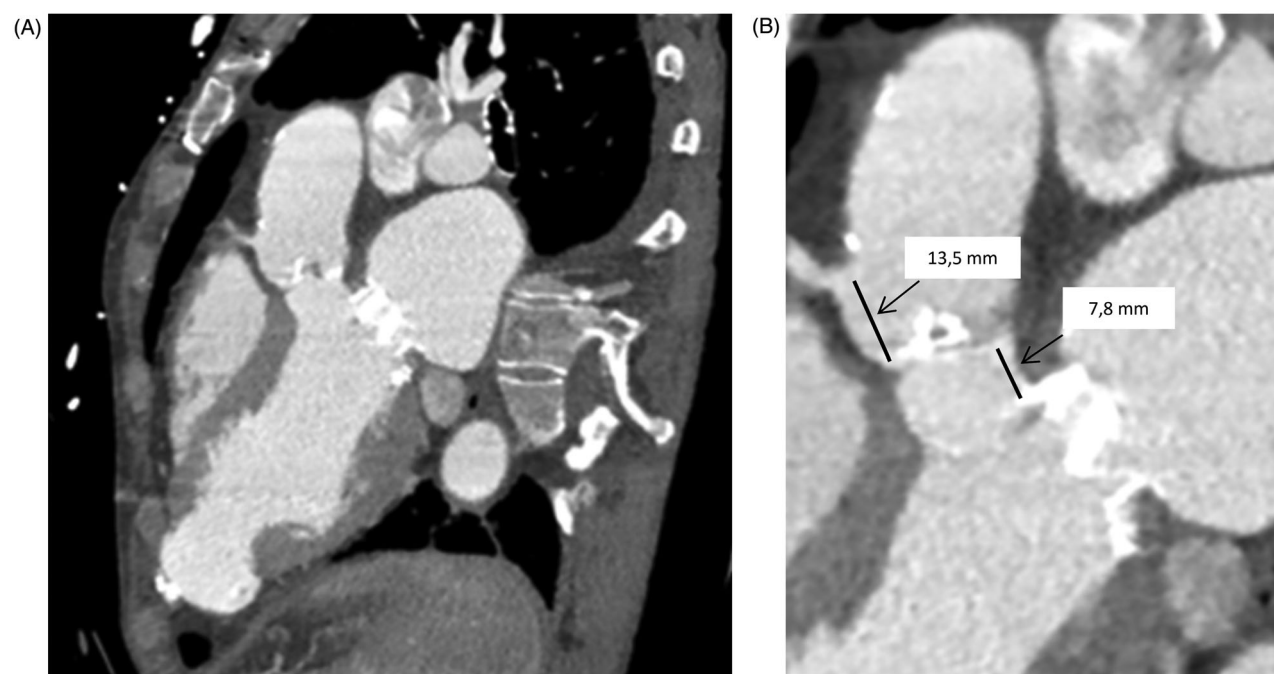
Procedural challenge in TAVI. Panel A: Besides the cicatricial apical aneurysm of the LV, CT showed a short distance between right coronary ostium and prosthetic mechanical mitral valve frame, measured at ± 21 mm, while the height of fully expanded 26-mm Edwards Sapien 3 is 20 mm. Panel B: zoom of the aortic valve apparatus.
